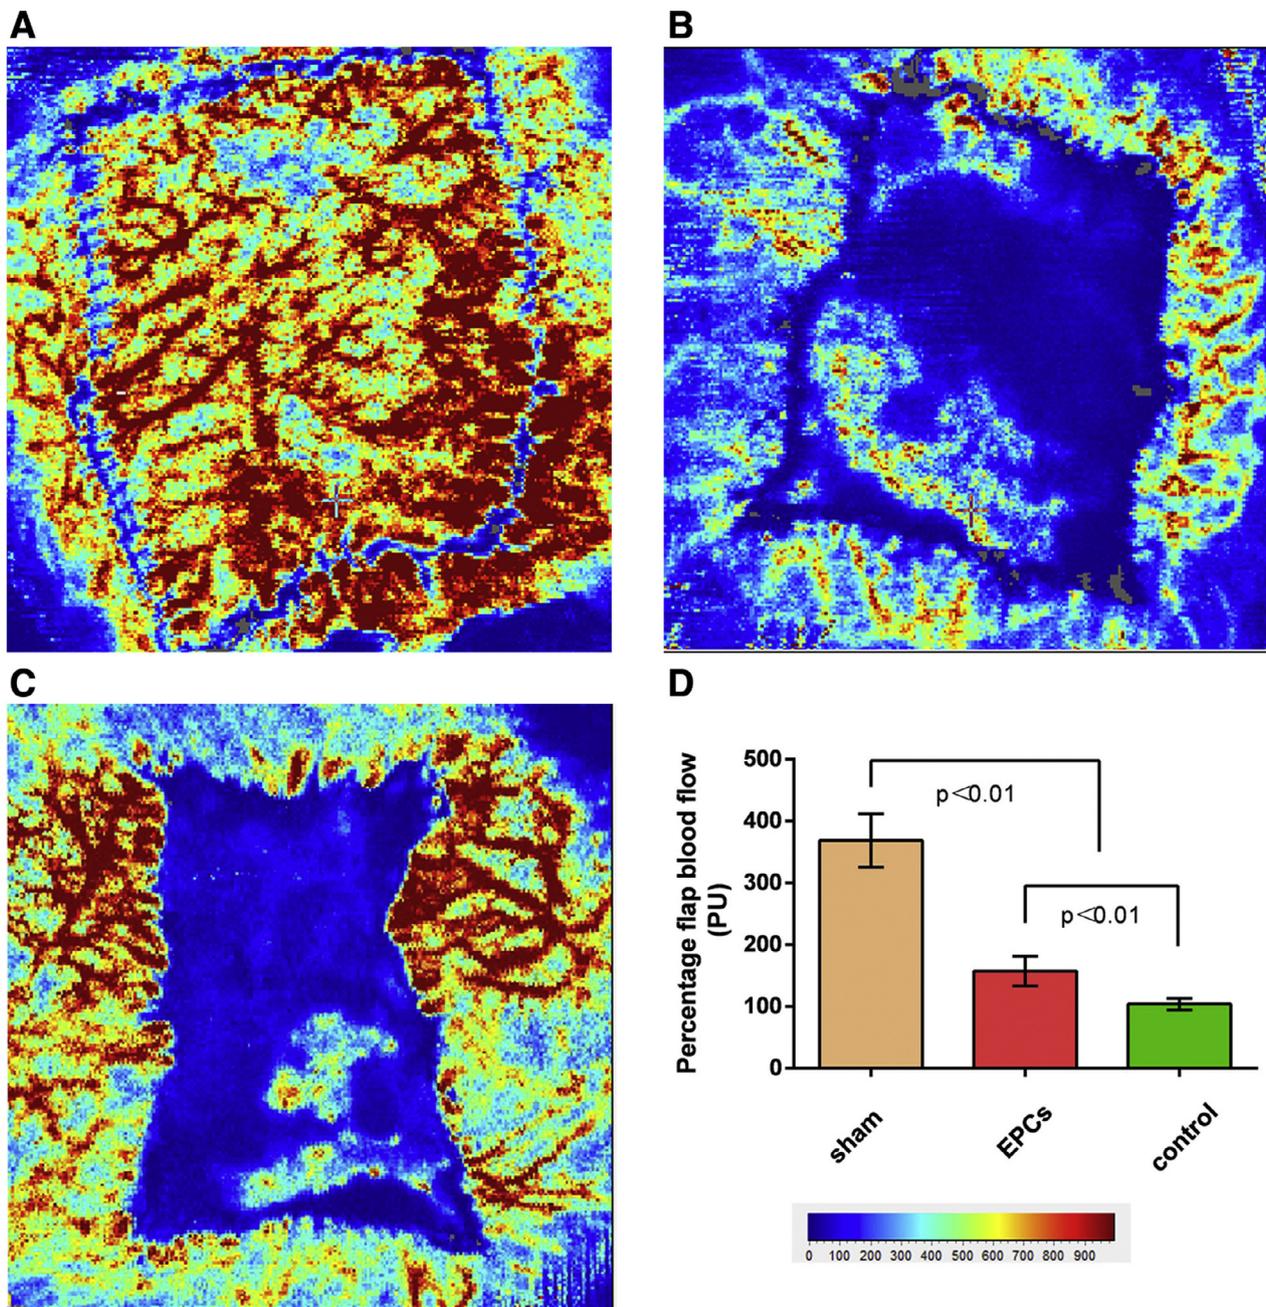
On the 10th day after operation, venous flaps were performed with full field laser Doppler perfusion imaging. (A, sham group; B, EPCs-transplantation group; C, control group; D, the percentage flap blood flow of three groups). Red showed high perfusion, blue showed low perfusion, and gray showed no perfusion. The scale indicates the color of the perfusion value.
